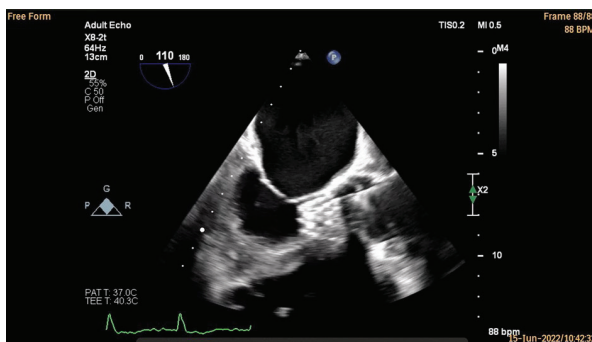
2D transoesophageal echocardiography – Long axis (LAX) aortic bioprosthesis malposition with displacement towards left ventricular outflow tract (LVOT)
